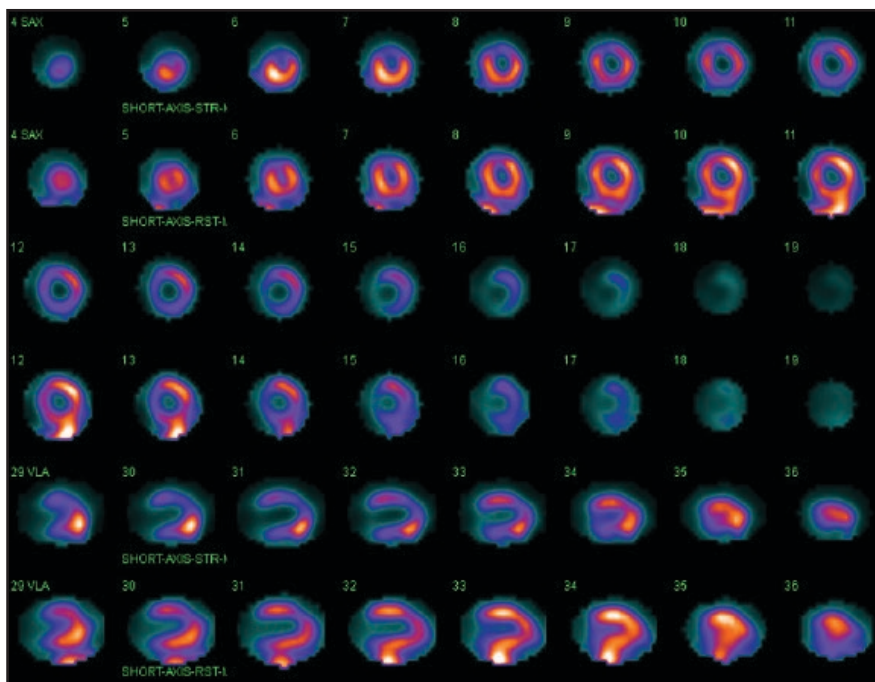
SA and VLA images from a SPECT MPI shows GI activity adjacent to the heart on the rest images, with GI counts seen joining the inferior wall.
